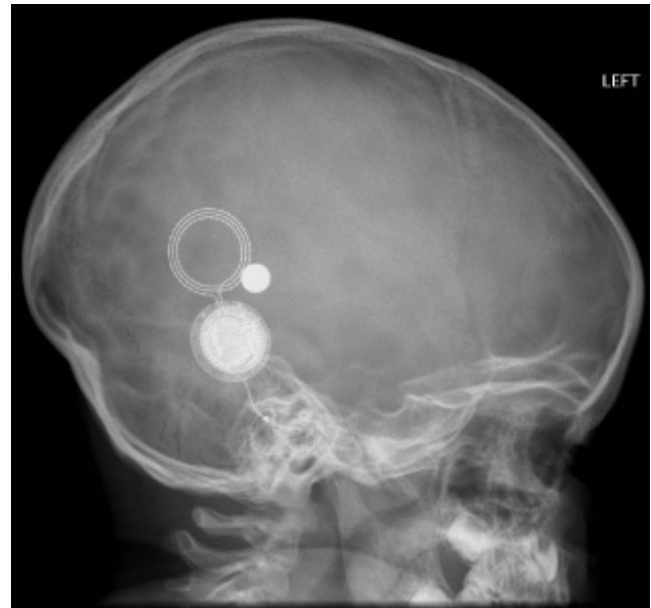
Plain lateral skull X-ray showing magnet displaced outside of the receiver-stimulator package.
